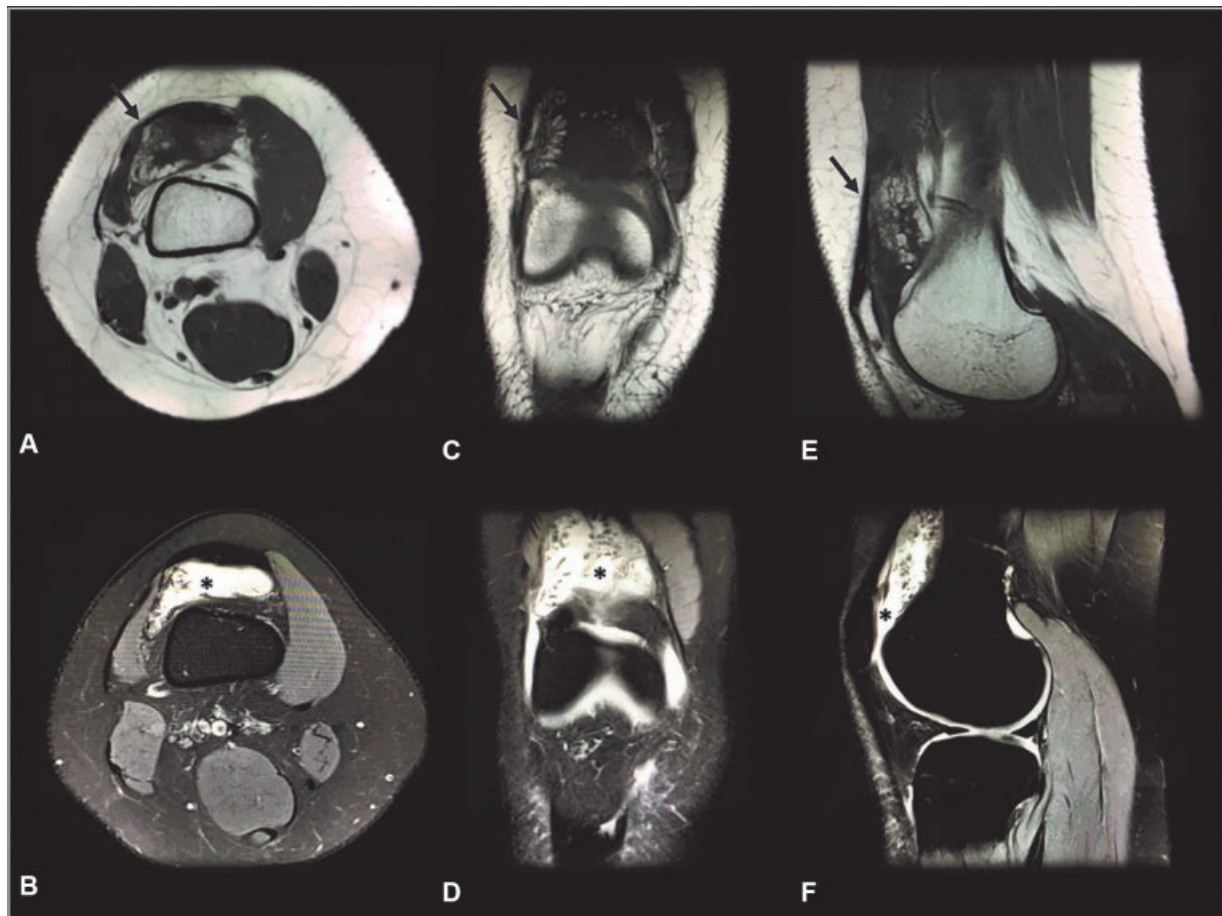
Magnetic resonance imaging of the right knee (case 1): upper images are T1-weighted axial (A), coronal (C) and sagittal (E) incidences showing the mass (black arrows) with intensity similar to subcutaneous fat and multiple villous projections of the synovium; lower images are proton density fat-saturated (PD-FS) axial (B), coronal (D) and sagittal (F) incidences, showing high intensity (*) compatible with a lipomatous tumor.
